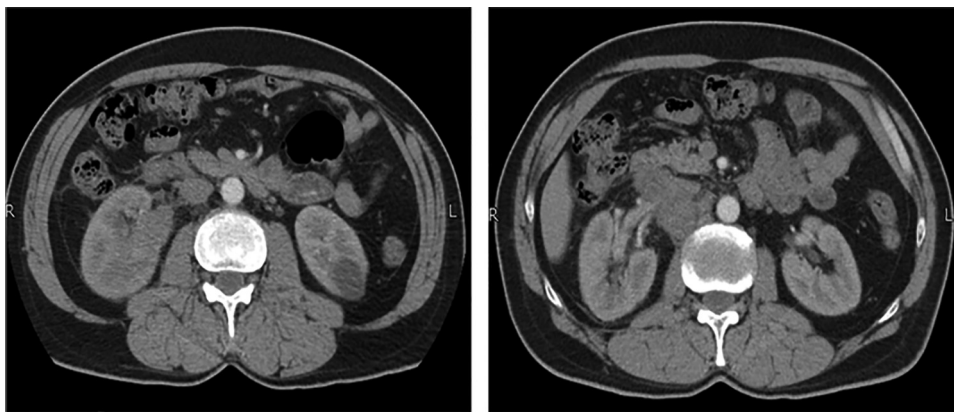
The CT scan shows a suspicious looking ill-defined infiltrating right infrahilar and lower pole renal lesion with a partly exophytic component. Multiple enlarged adjacent centrally necrotic lymph nodes in the aortocaval and retrocaval locations.
